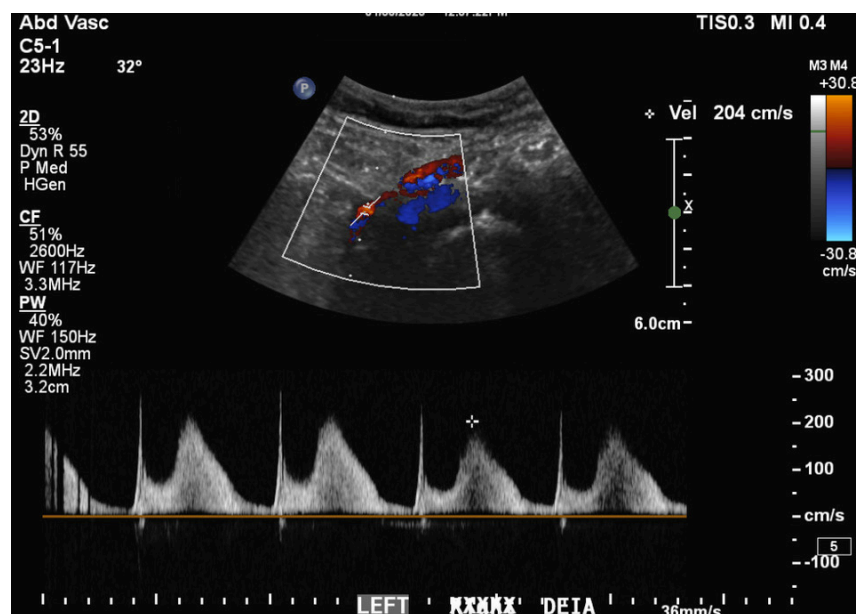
Ultrasonographic image of the left external iliac artery demonstrating dissection flap with pulsed Doppler spectral waveform with a rapid systolic upstroke followed by a systolic cleft and dome.
